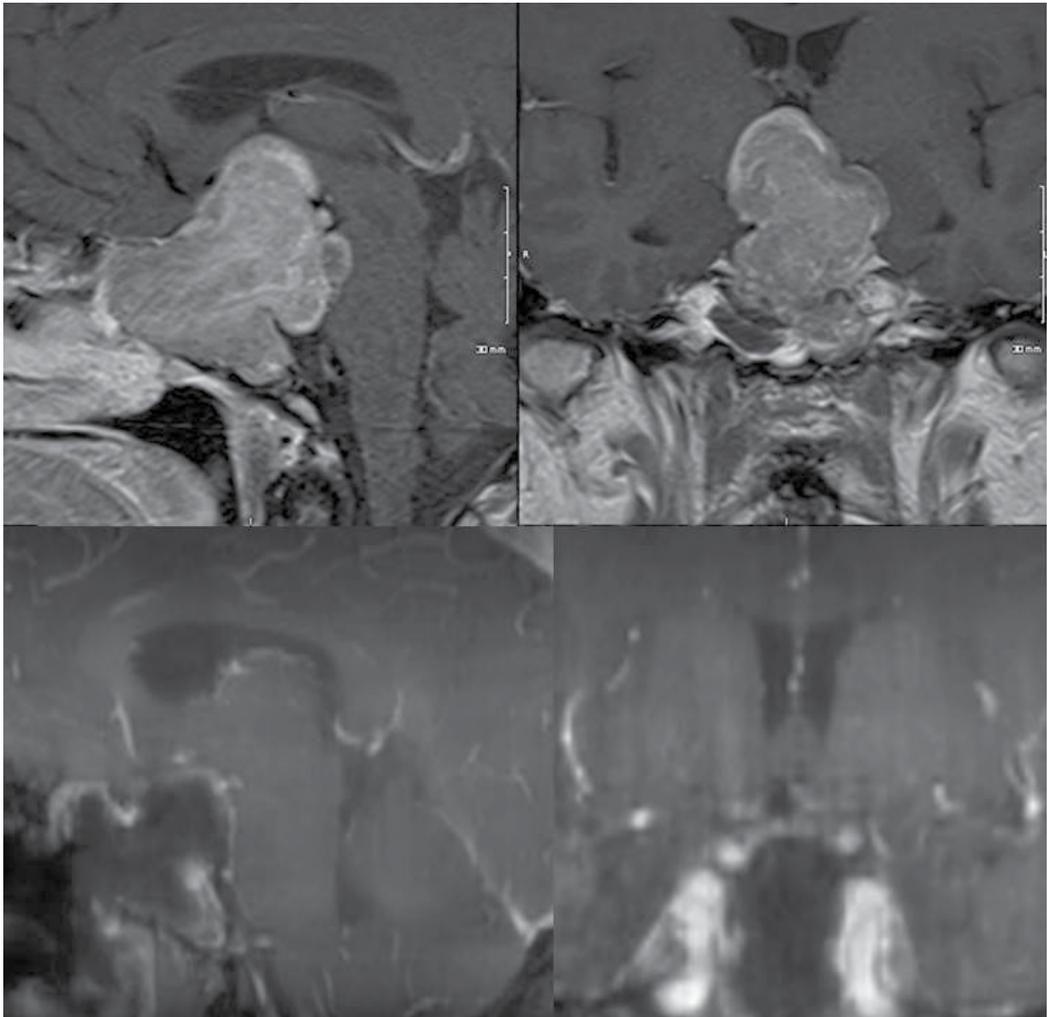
Post contrast T1-weighted sagittal and coronal preoperative (upper) and intraoperative (lower) images from a patient with a giant pituitary macroadenoma.
